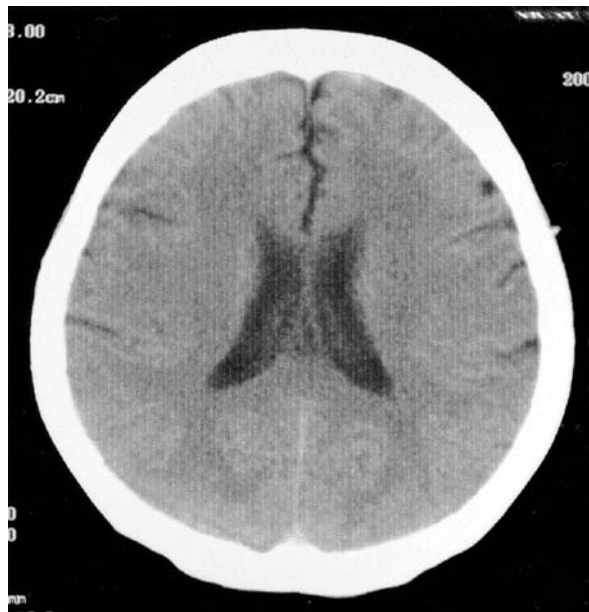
A head CT scan on November 19, 2001. The low-density areas that had been seen before have disappeared
